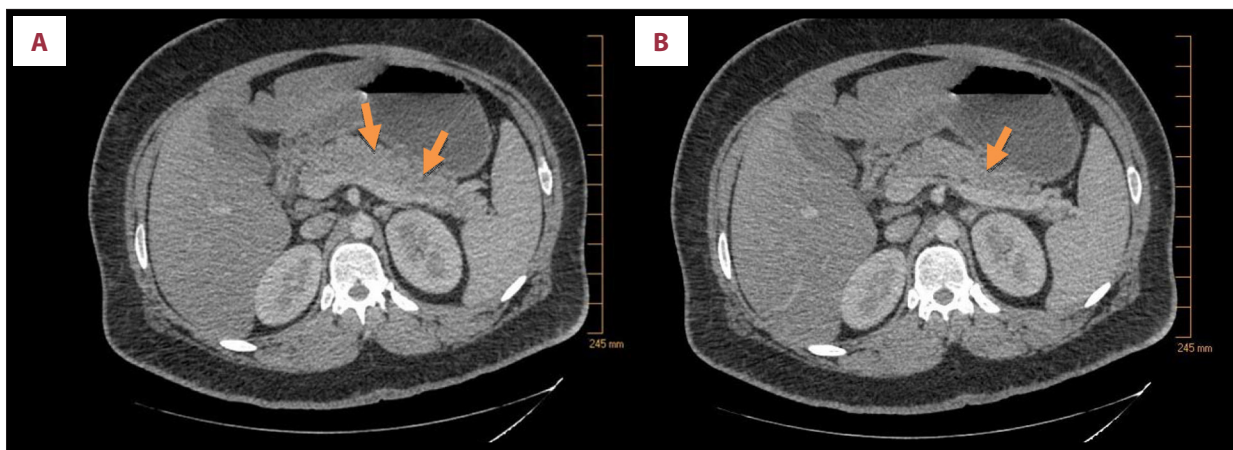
(A, B) Computed tomography images showing pancreatic inflammation (arrows) and induration surrounding the head of pancreas.
